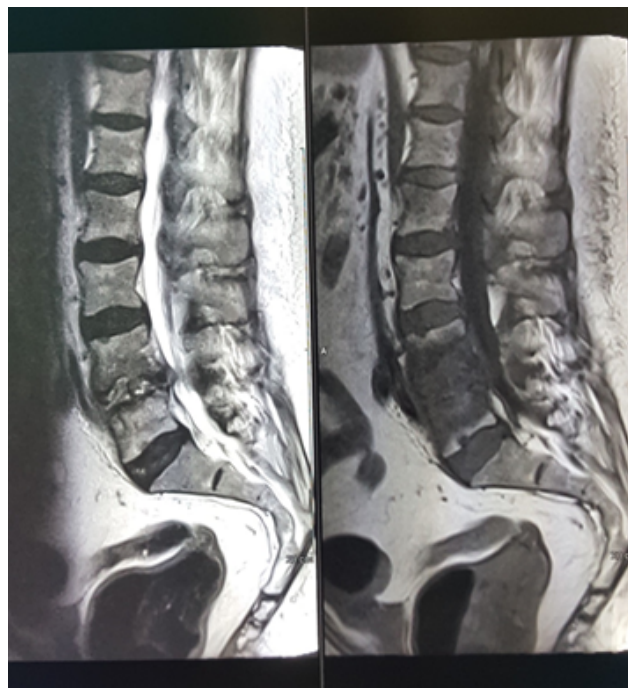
MRI of the lumbosacral spine without gadolinium contrast showing discitis at the L4–L5 level (patient n. 6)
